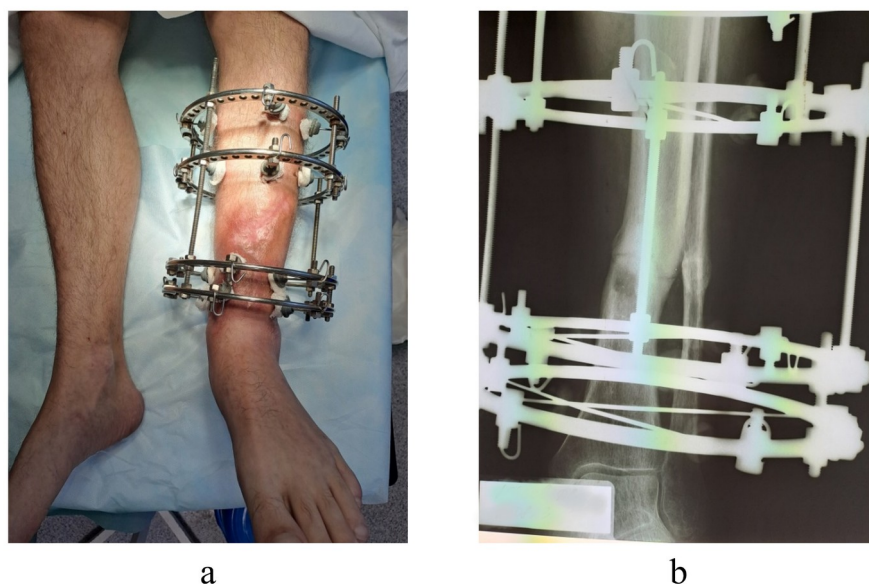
Clinical appearance (a) and radiographic findings (b) of the left shin in patient Yu., 43 years old, at 7-month postoperative follow-up
